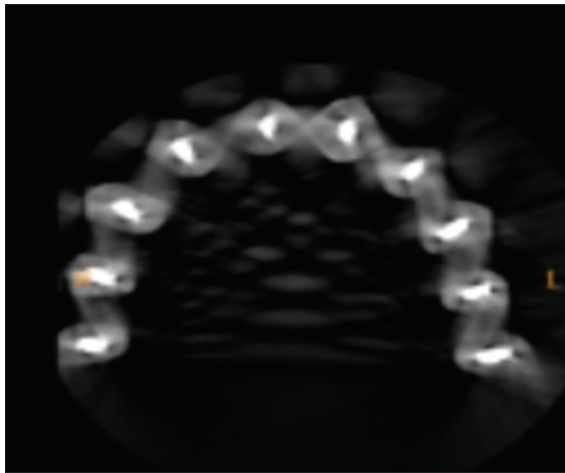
Cone beam computed tomography data acquisition in digital imaging and communications in medicine format
